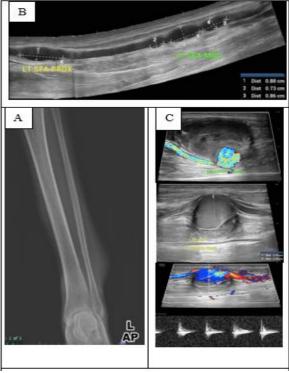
A) Anterior left leg radiograph showing soft tissue swelling in the lateral and medial aspects of the distal leg; B) Ultrasound of the left lower limb showed multiple pseudoaneurysms in the left superficial femoral artery; C) Color Doppler ultrasound showed classic yinyang sign in the body of the pseudoaneurysm.
